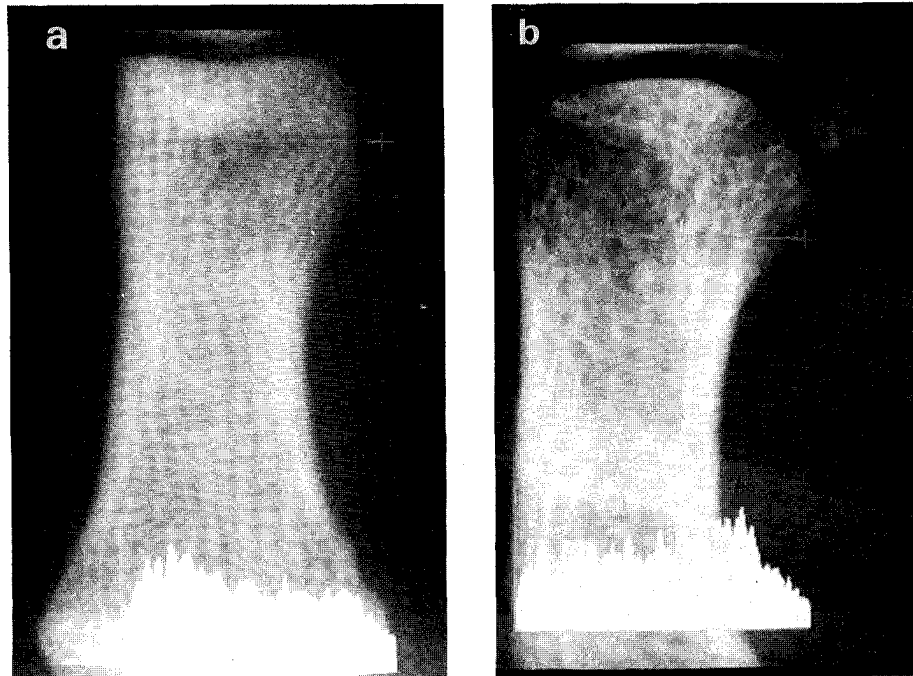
(a) Postmortem radiograph of the right proximal first; (b) postmortem radiograph of the right first metacarpal phalanx.
